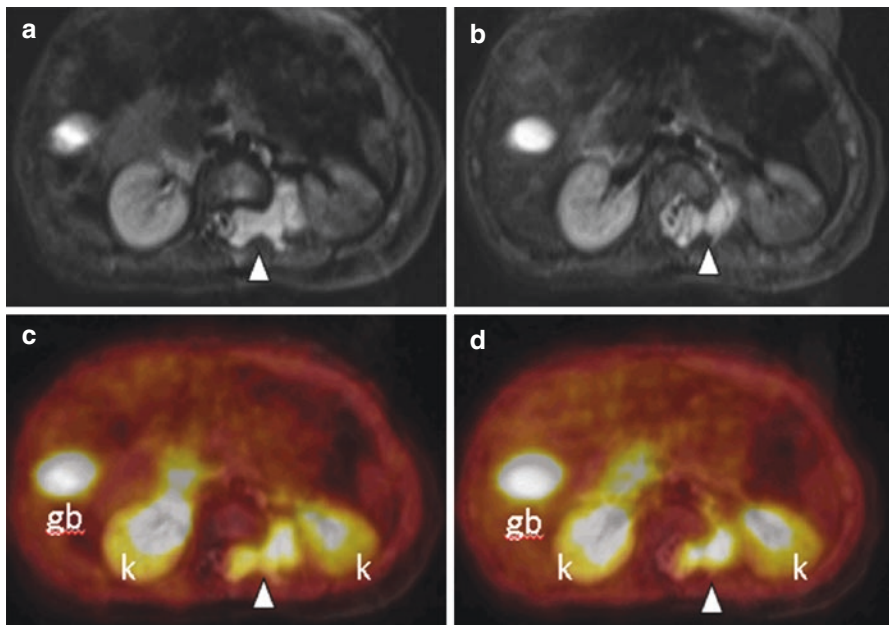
FDOPA-PET/MRI performed in a 2-year old boy undergoing initial staging for a neuroblastoma. The T2 fat saturated MR images (a, b) show a lobulated T2 hyperintense mass involving the central spinal canal, a spinal neuroforamen and the left paraspinal region (*arrow head*) representing the primary tumor. This lesion demonstrates increased uptake of FDOPA on the fused PET/MRI images (c, d). No metastases were identified. Note the normal excreted activity in the kidneys (*k*) and gallbladder (*gb*). *This figure is courtesy of Drs. Franz Wolfgang Hirsch and Regine Kluge from the University Hospital of Leipzig, Germany.* (a, b) T2 fat sat; (c, d) fused FDOPA-PET/MRI
